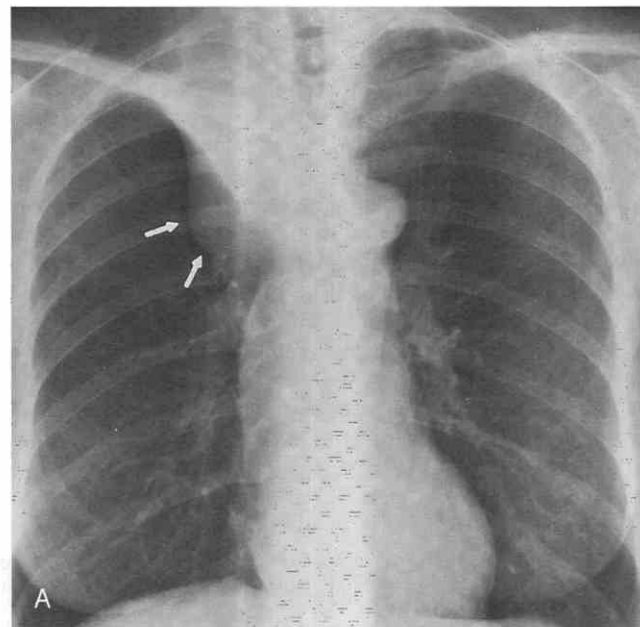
Squamous cell lung cancer seen as a central endobronchial mass. A, Posteroanterior chest radiograph shows complete atelectasis of the right upper lobe. Convexity in the lower portion of the atelectatic lung (arrows) is the result of a large central mass. B, CT confirms the large central mass in the region of the right upper lobe bronchus.
